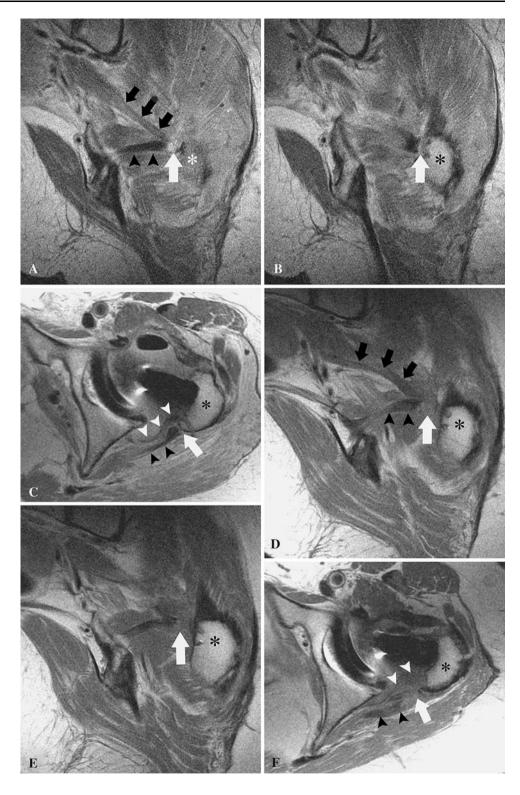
F (A-C): MR images 3 days following total hip arthroplasty. Coronal image through the posterior soft tissue repair (A) demonstrates the piriformis tendon (black arrows) and the obturator internus tendon (black arrowheads) converging towards the greater trochanter (asterisk). Adjacent coronal image (B) demonstrates the distal margins of the tendons apposing the greater trochanter (asterisk) to form an intact posterior soft tissue repair (white arrow). Axial image (C) demonstrates an intact posterior capsule (white arrowheads) attached to the greater trochanter (asterisk). The intact obturator internus tendon repair (black arrowheads and white arrow) is once again noted. (D-F): MR images 3 months following surgery. Coronal image through the posterior soft tissue repair (D) demonstrates mildly thickened and scarred piriformis tendon (black arrows) and the obturator internus tendon (black arrowheads) converging towards the greater trochanter (asterisk). The adjacent coronal image (E) demonstrates the distal margins of the tendons apposing the greater trochanter (asterisk) where there is progressive soft tissue scarring at the site of an intact posterior soft tissue repair (white arrow). Axial image (F) demonstrates an intact and scarred posterior capsule (white arrowheads) attached to the greater trochanter (asterisk). The intact obturator internus tendon repair (black arrowheads and white arrow) is once again noted.
